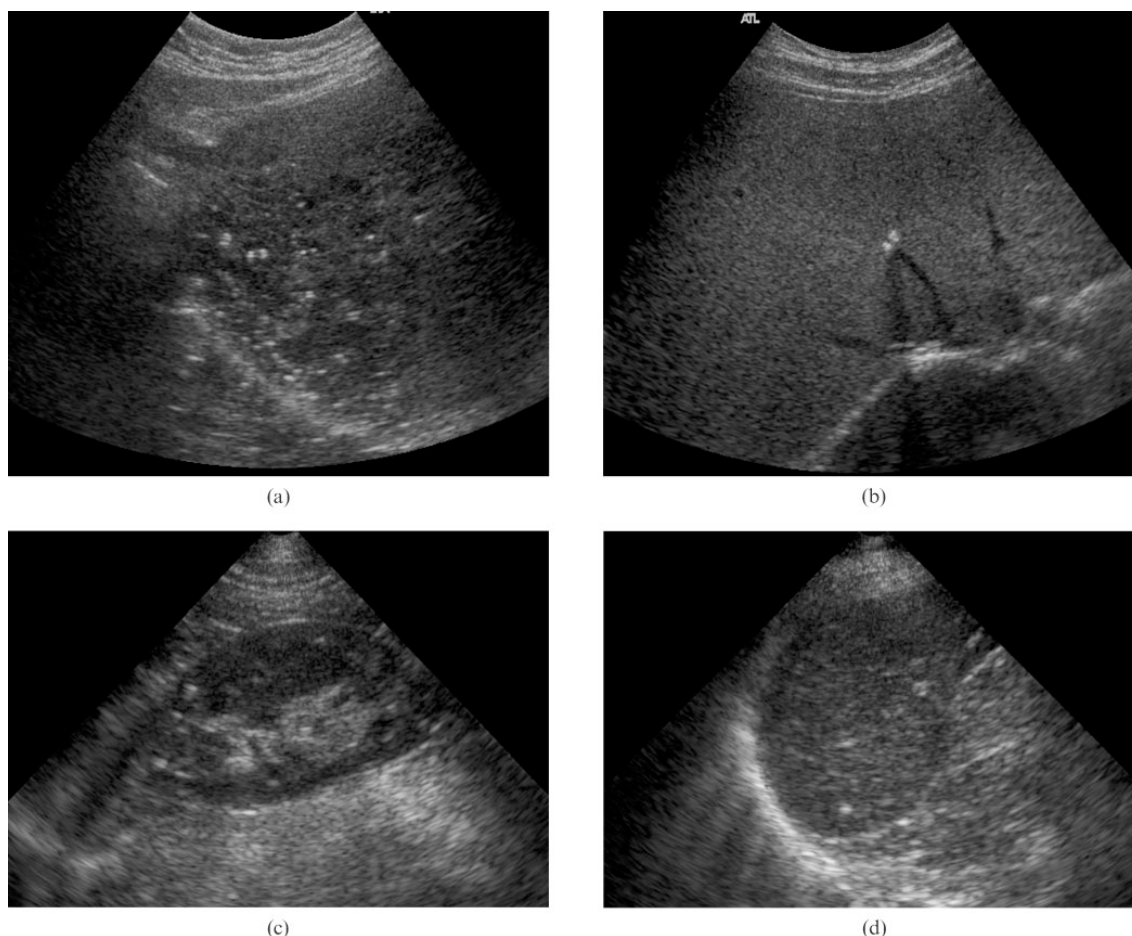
Ultrasound images of calcified foci in several abdominal organs: (a) frontal cross-section through the abdomen with multiple calcifications in the liver of a pseudoxanthoma elasticum (PXE) patient; (b) subcostal transverse cross-section of the liver of a heterozygous carrier in which two calcifications with acoustic shadowing are seen; (c,d) frontal cross-section through the abdomen with view of multiple hyperechogenic foci in (c) the right kidney and (d) spleen of PXE patients.
